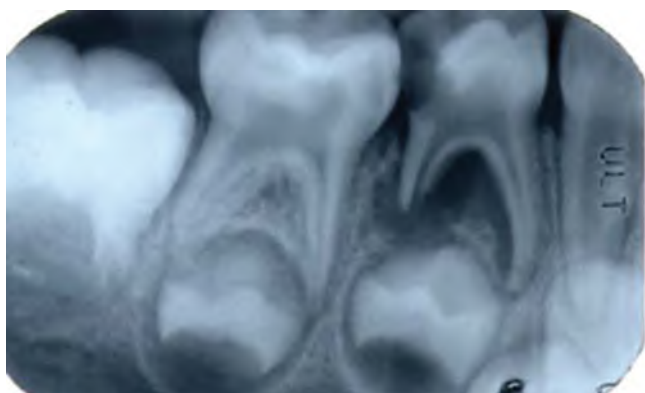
Periapical radiograph showing an interdicular and periapical radiolucent area associated with the primary mandibular right first molar. Note that the radiolucent area has already included the bone compacta surrounding the follicle of the permanent successor.
